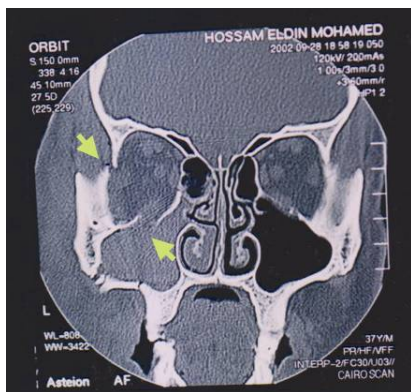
Photograph showing coronal cut CT of case 3 fracture of the lateral and inferior orbital rim.
